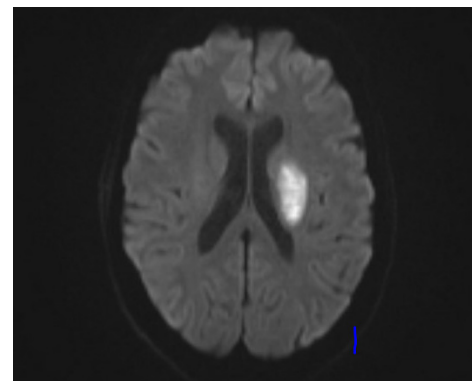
Magnetic resonance imaging showing left basal ganglia infarct.
